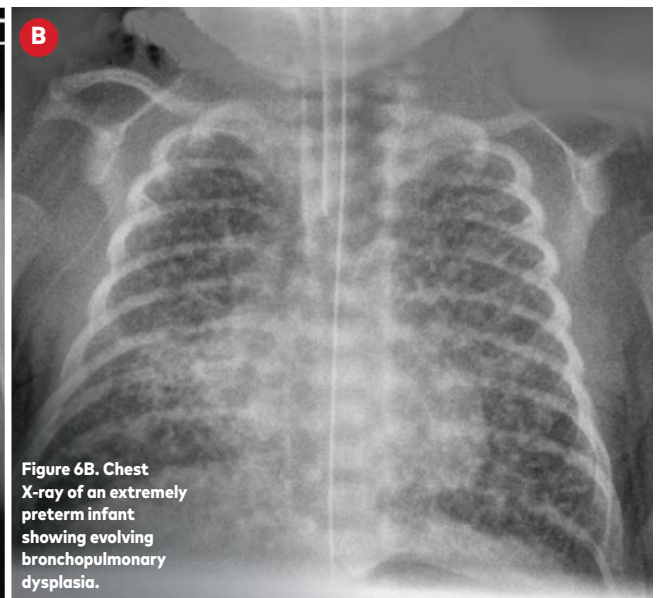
Chest X-ray of an extremely preterm infant showing evolving bronchopulmonary dysplasia.
